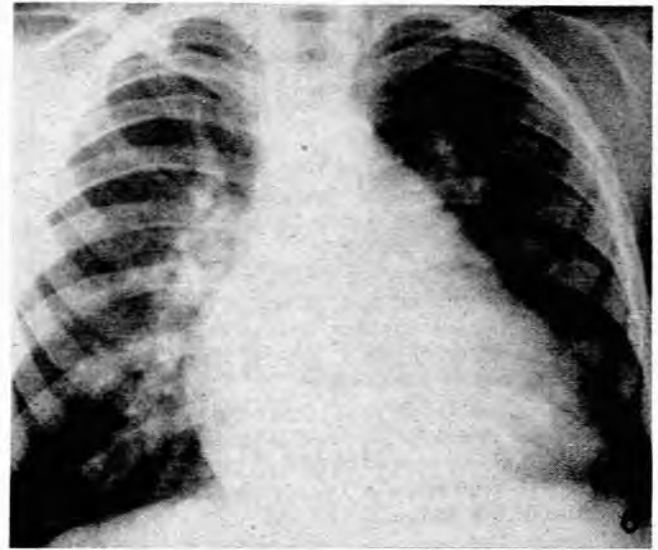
Radiograph showing well-marked pulmonary plethora in a patient with moderate pulmonary hypertension.
